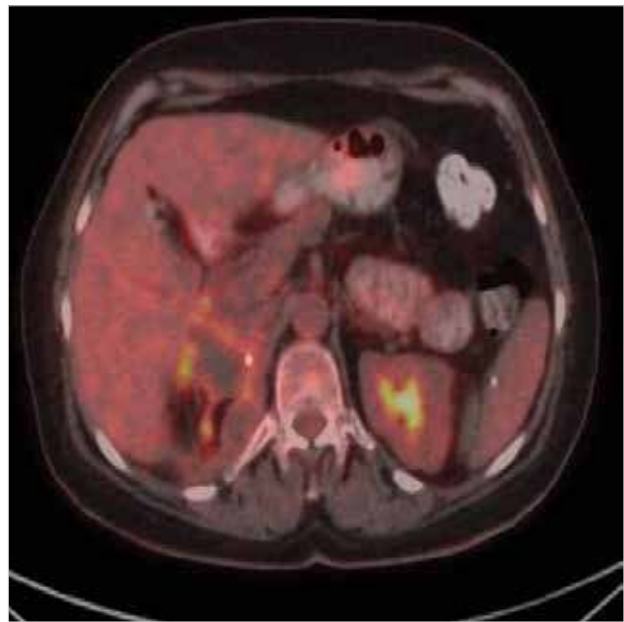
PET-CT scans of the patient after surgery
